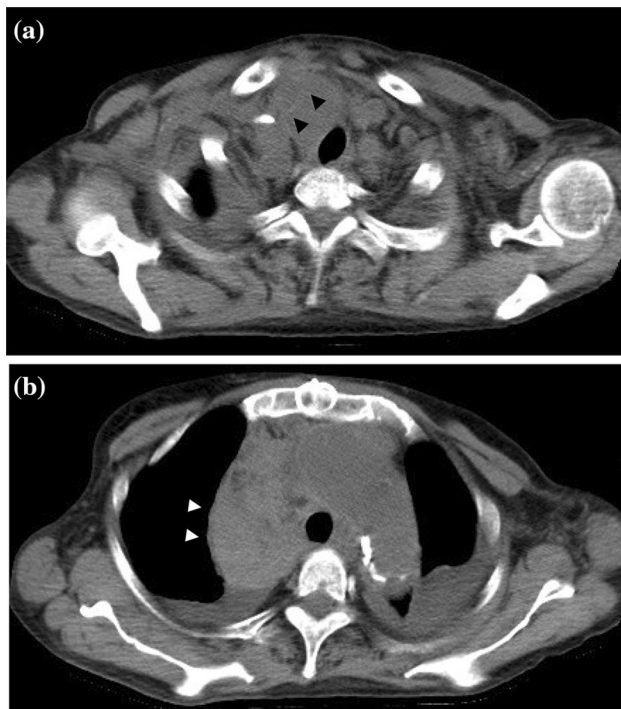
Chest CT scans of the patient showed aortic dissection accompanied by mediastinal hematoma. Chest CT scans performed after the dialysis on the next day of admission revealed an intimal flap in brachiocephalic trunk (a) and mediastinal hematoma (b)
